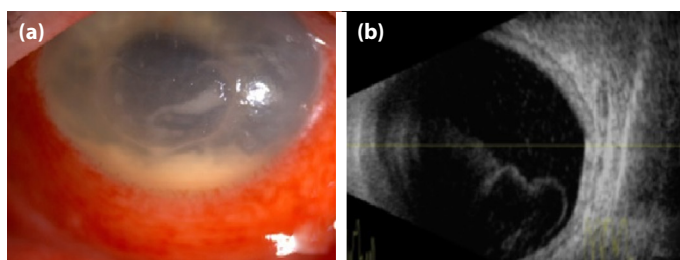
(a) Ciliary hyperemia, corneal edema, corneal epithelial defect, intense cellular reaction, and hypopyon in the anterior chamber; (b) condensed view in the vitreous on ocular ultrasound.
